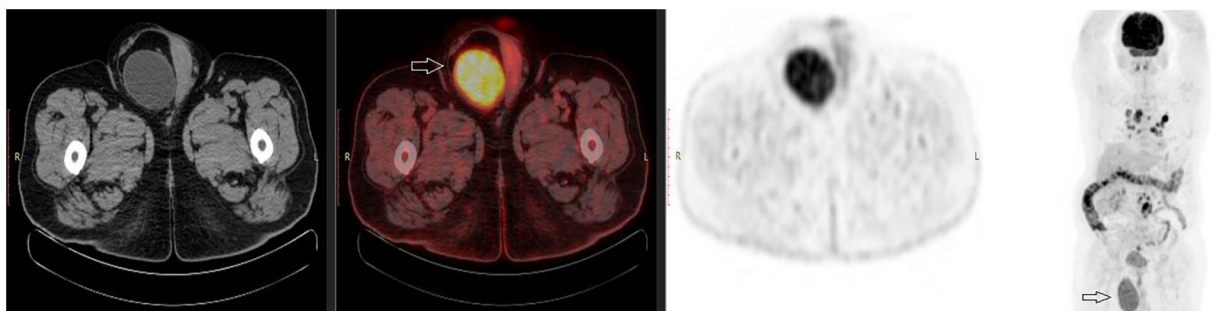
F-18 FDG accumulation in the right inguinoscrotal region on PET/CT images and hypodense lesion in this area on CT images (arrow). Involvement in the right inguinoscrotal area at the same level as the bladder in MIP images (arrow).
